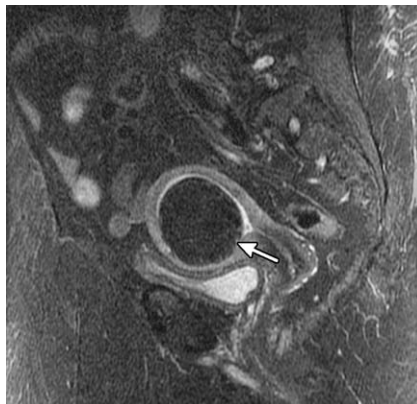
Sagittal T2-weighted scan demonstrates large submucosal fibroid (*arrow*) that is low signal, which is typical of hyaline change.
